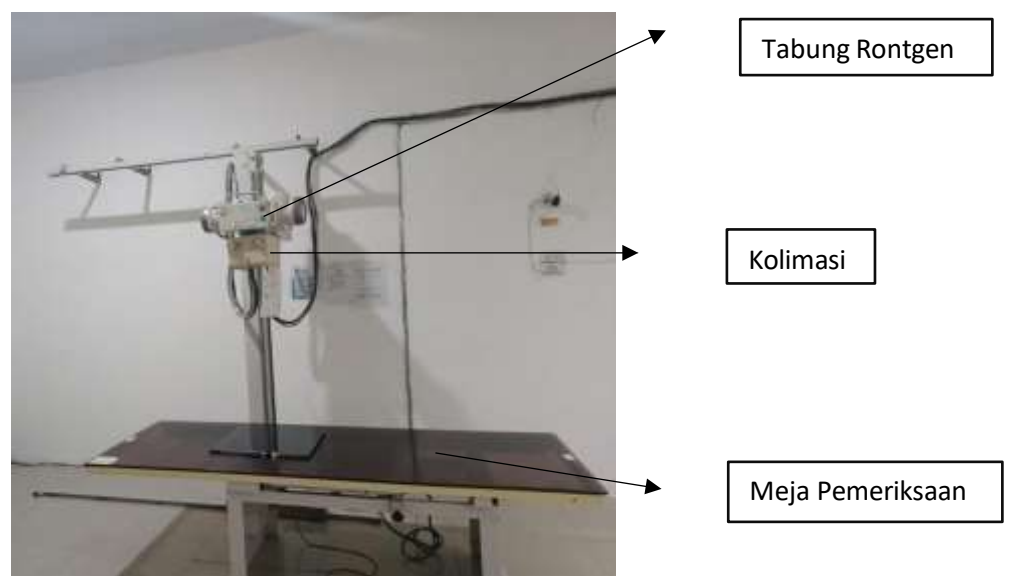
Digital Radiography Plane
